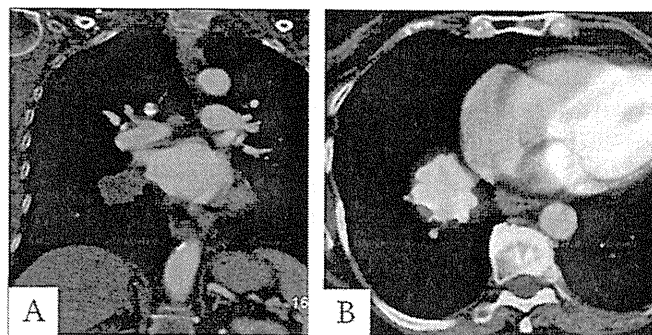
CT and FDG-PET of invasive mucinous adenocarcinoma. *A*, Coronal CT and (*B*) FDG-PET images show a hypermetabolic hypodense solid 4 cm mass in the right lower lobe. CT, computed tomography; FDG-PET, fluorodeoxyglucose positron emission tomography.
